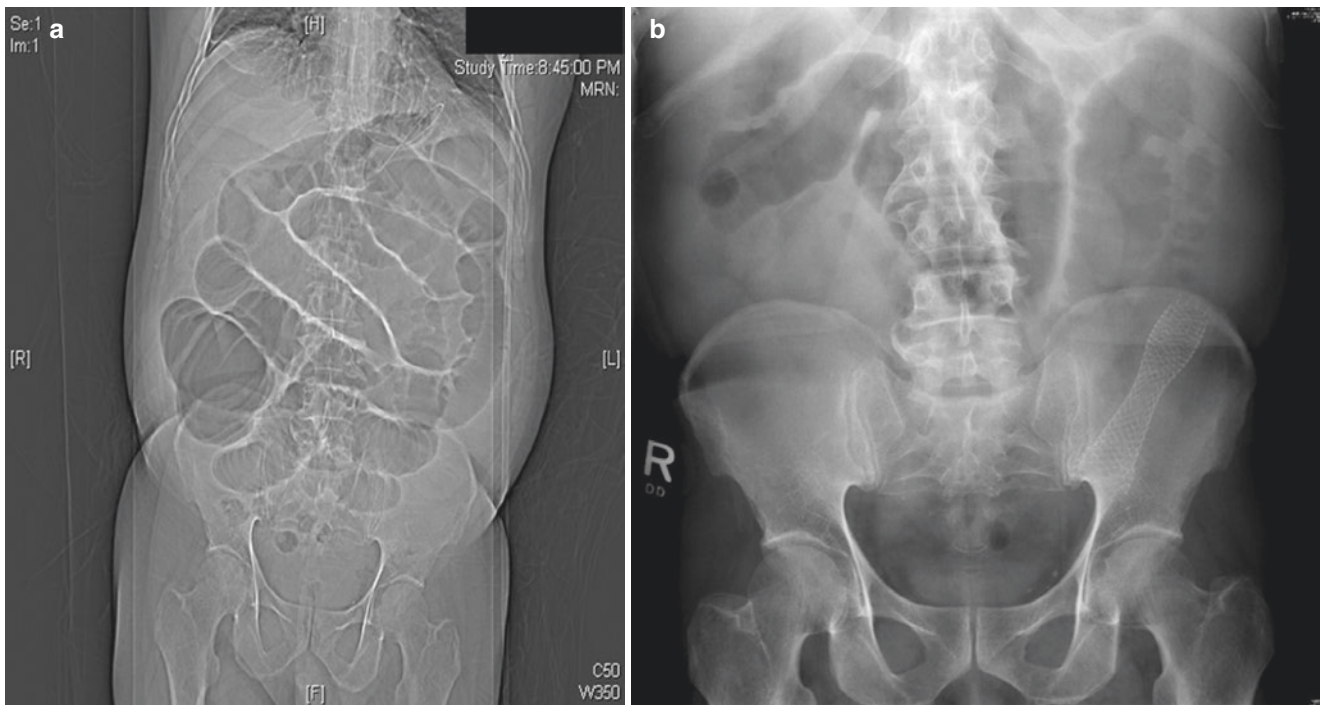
(a) CT scan topogram demonstrating small bowel obstruction secondary to a large bowel obstruction in a patient with an obstructing left colon cancer with an incompetent ileocecal valve. (b) Abdominal
